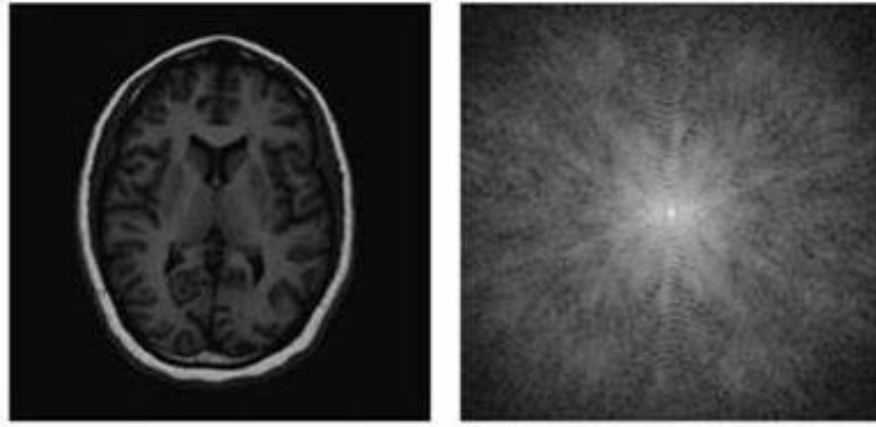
Left: MRI  $T_1$  weighted image of the brain. Right: corresponding  $k$ -space image [79].
